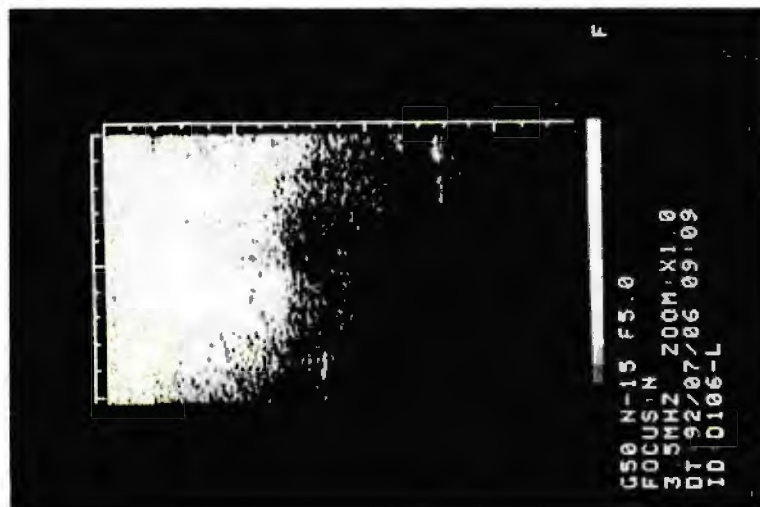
Ultrasonogram of severe fatty change if the liver.
